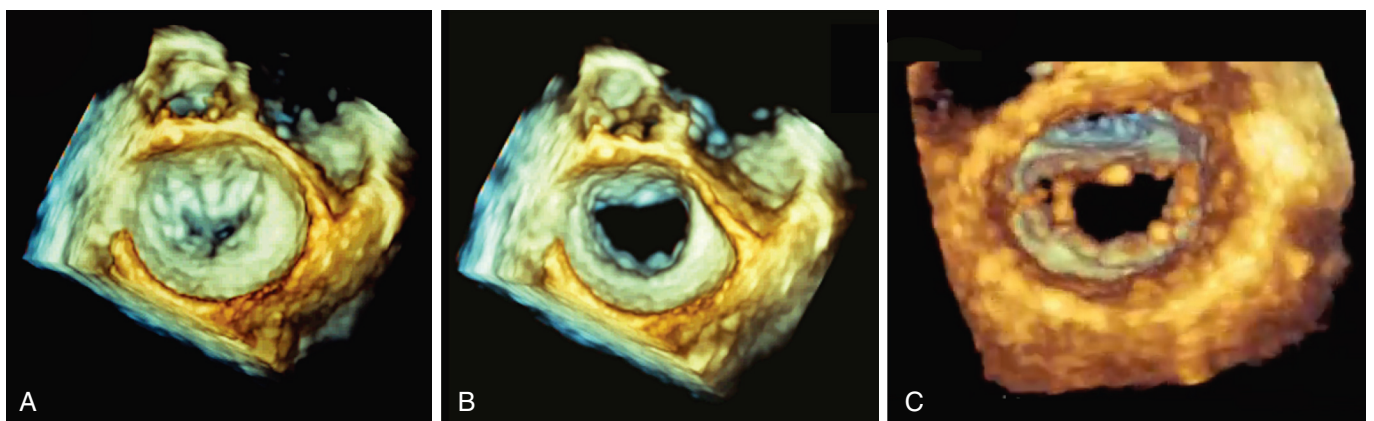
■ Mitral valve open/closed. En face view of the mitral valve obtained with three-dimensional transesophageal echocardiography demonstrates the valve in a closed (A) and open position (B). The image can then be rotated to reveal valve anatomy as seen from the left ventricle (C).
